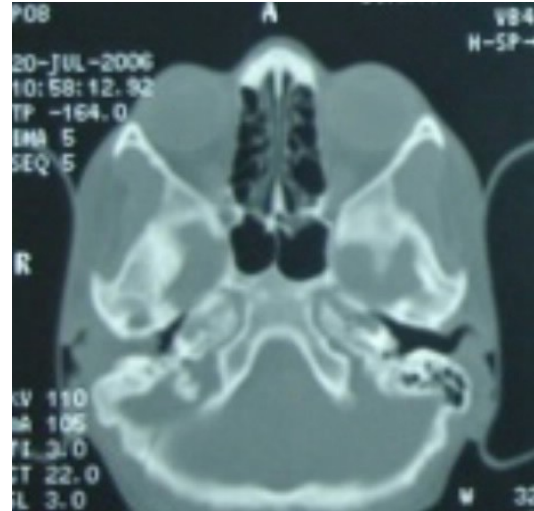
CT scan of the temporal bone showing soft tissue density in external auditory canal, middle ear and mastoid antrum in right ear.
